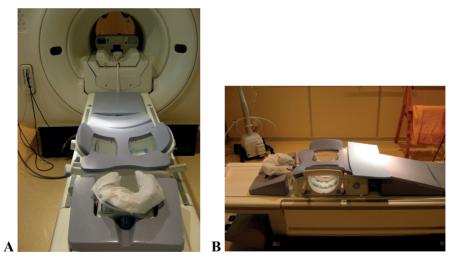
A. MRI scanners use a strong magnetic field and radiofrequency pulses to create high resolution images. B. A dedicated double breast surface coil is essential to permit simultaneous high-resolution and high-quality imaging of the breasts. By courtesy of Dr Anders Karlsson.
